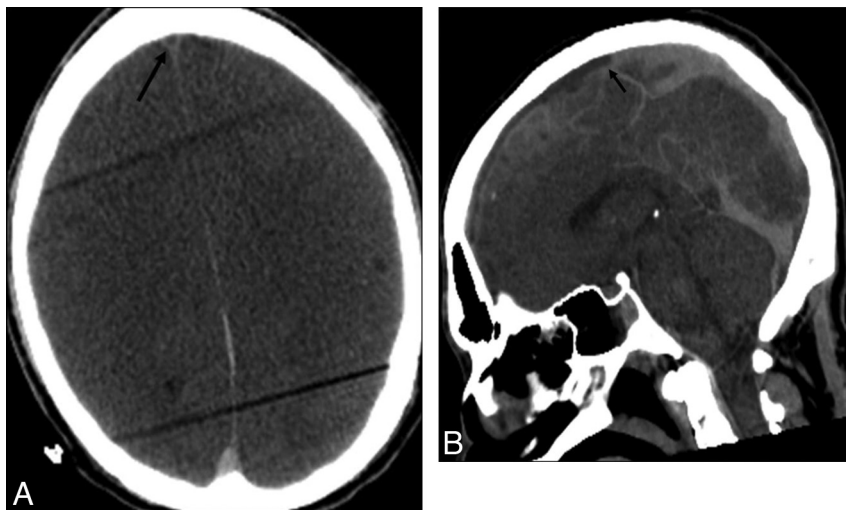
Hematocrit effect. *A*, Axial noncontrast CT reveals high attenuation within the posterior aspect of the sagittal sinus but low attenuation within the anterior aspect of the sinus (arrow). Beam-hardening artifact is caused by the grommets on the body bag. *B*, Sagittal reformation demonstrates the fluid–fluid level in the sagittal sinus (arrow).
